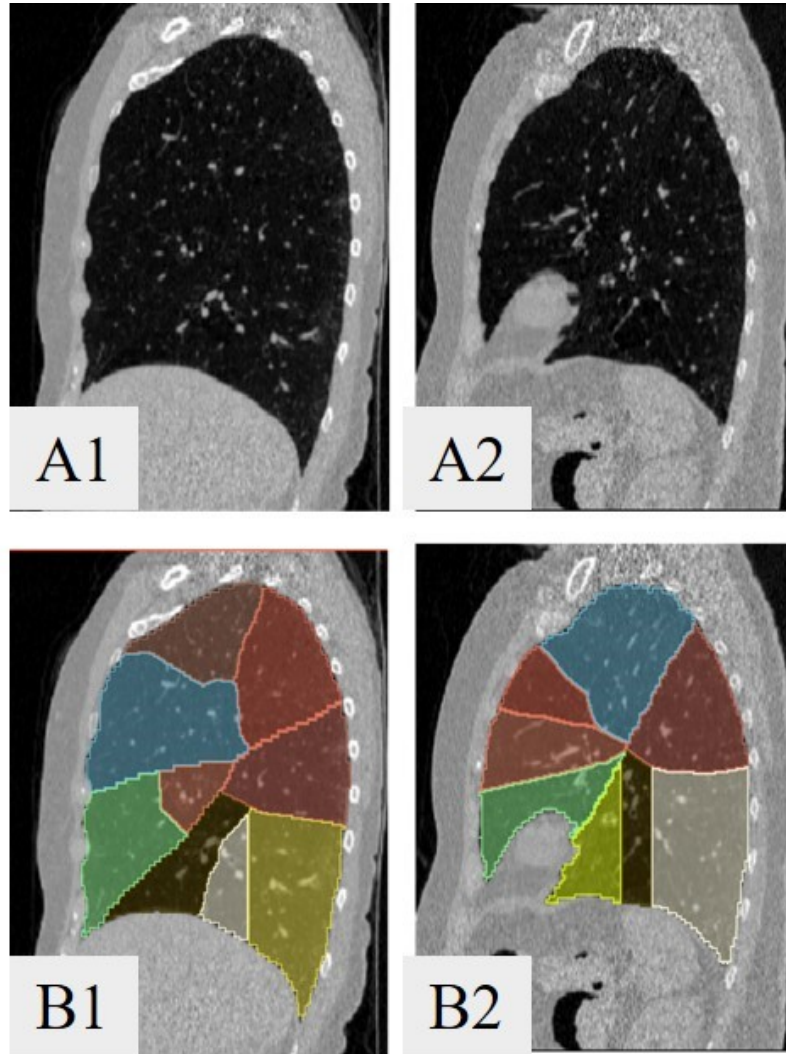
The sagittal view of two patients with the CT images (A), pulmonary segments mask with CT image (B).
